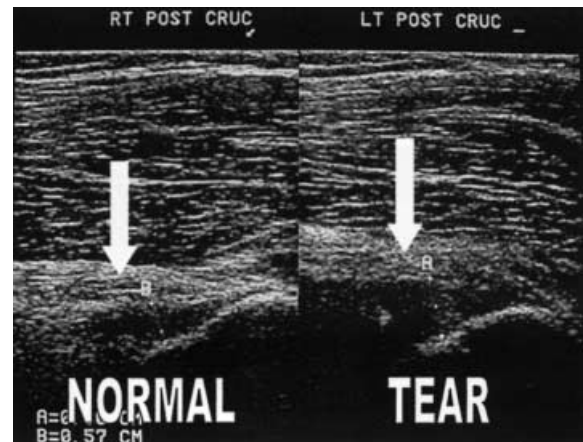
Posterior cruciate ligament tear. Ultrasound demonstrates abnormal thickening of the visualized posterior cruciate ligament compared with the normal contralateral side
